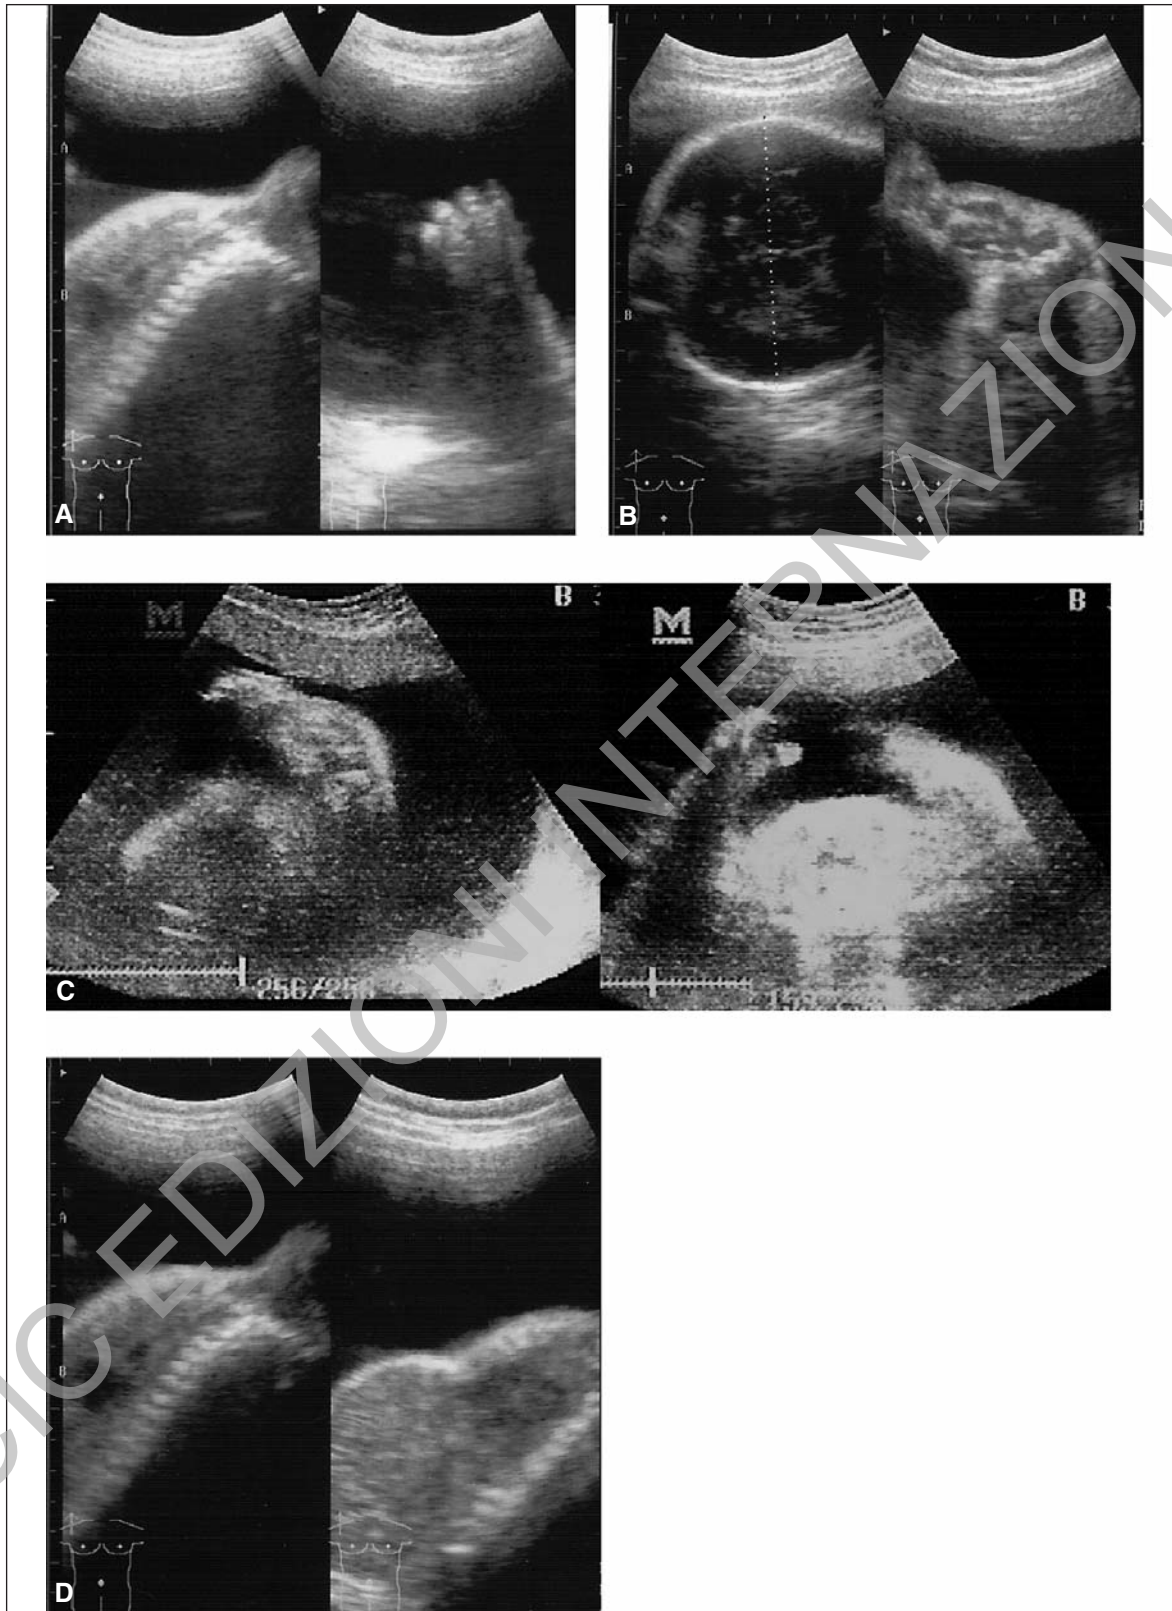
Prenatal sonograms of a thanatophoric dwarf. (A) Demonstrate fetal trunk (right) and fetal hand (left) at 32weeks gestational age; (B) demonstrated fetal skull and the short lower limb; (C) Shows both upper limbs of the fetus in persistent embracing position, and (D) Shows narrowed fetal trunk and the protuberous abdomen fetal trunk. Note the persistence of fetal neck in extension, the widened intervertebral spaces and tongue-like projections of the vertebral bodies anteriorly in (A) and (D).
